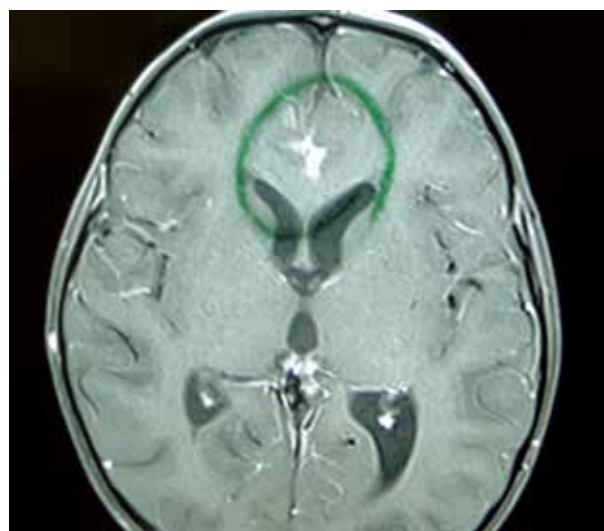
Brain MRI Revealing Leptomeningeal Enhancement in Frontal Lobe, Consistent With Pachymeningitis
